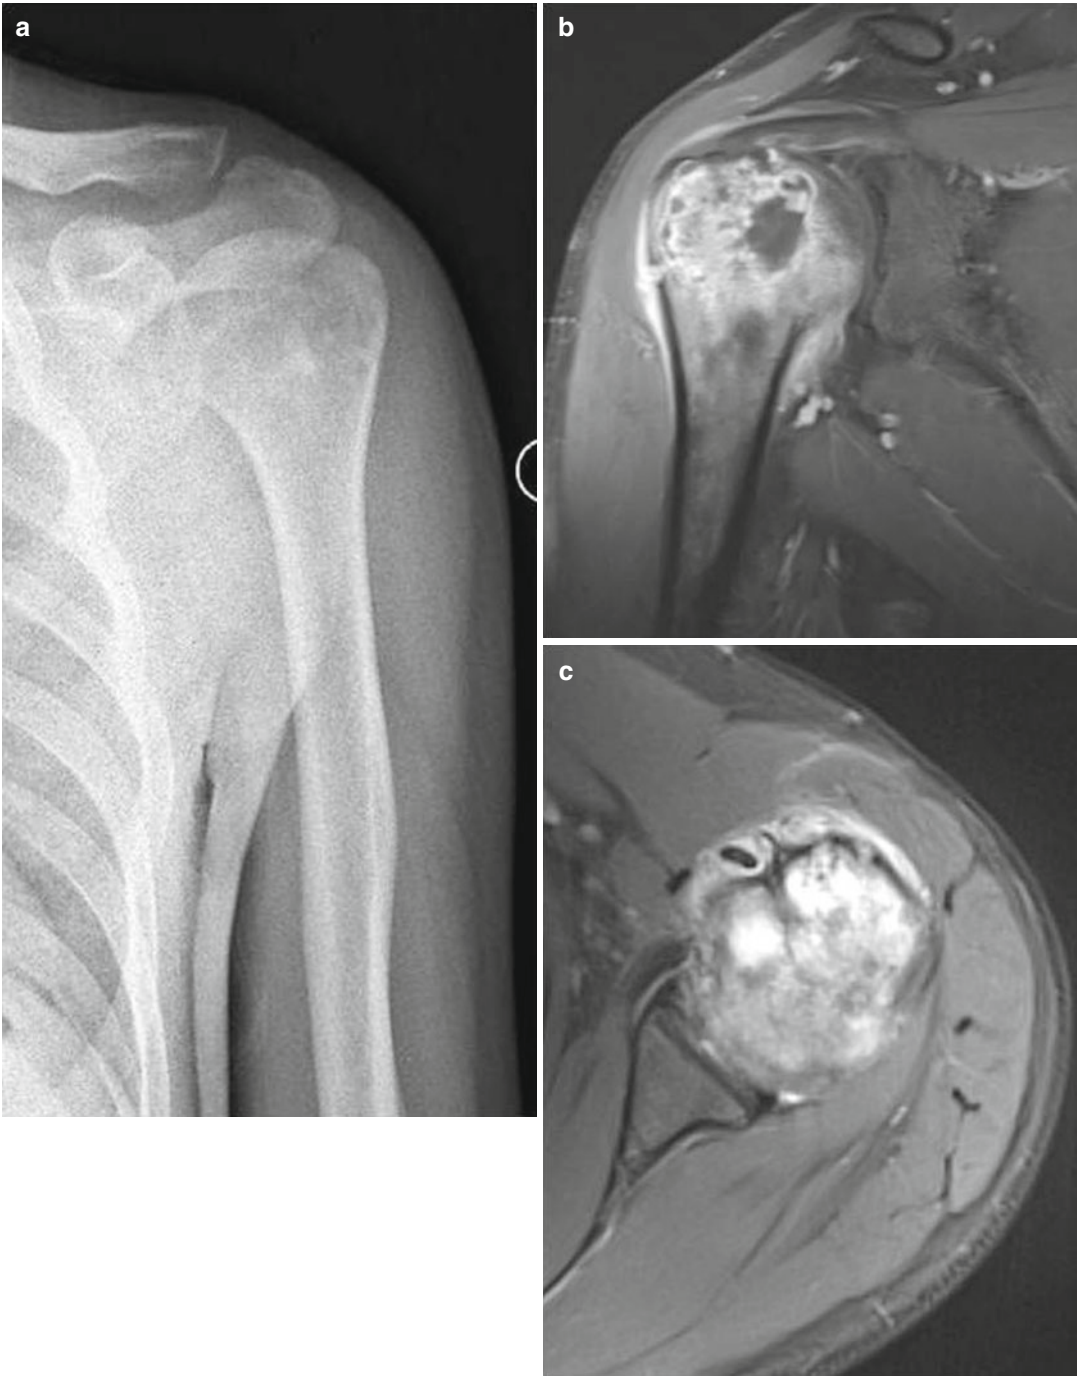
High-grade chondrosarcoma. (a) Intralesional calcifications of lytic lesion in proximal humerus can be seen on conventional radiographs. Tumor did not cause a significant cortical erosion. (b, c) Intramedullary involvement
